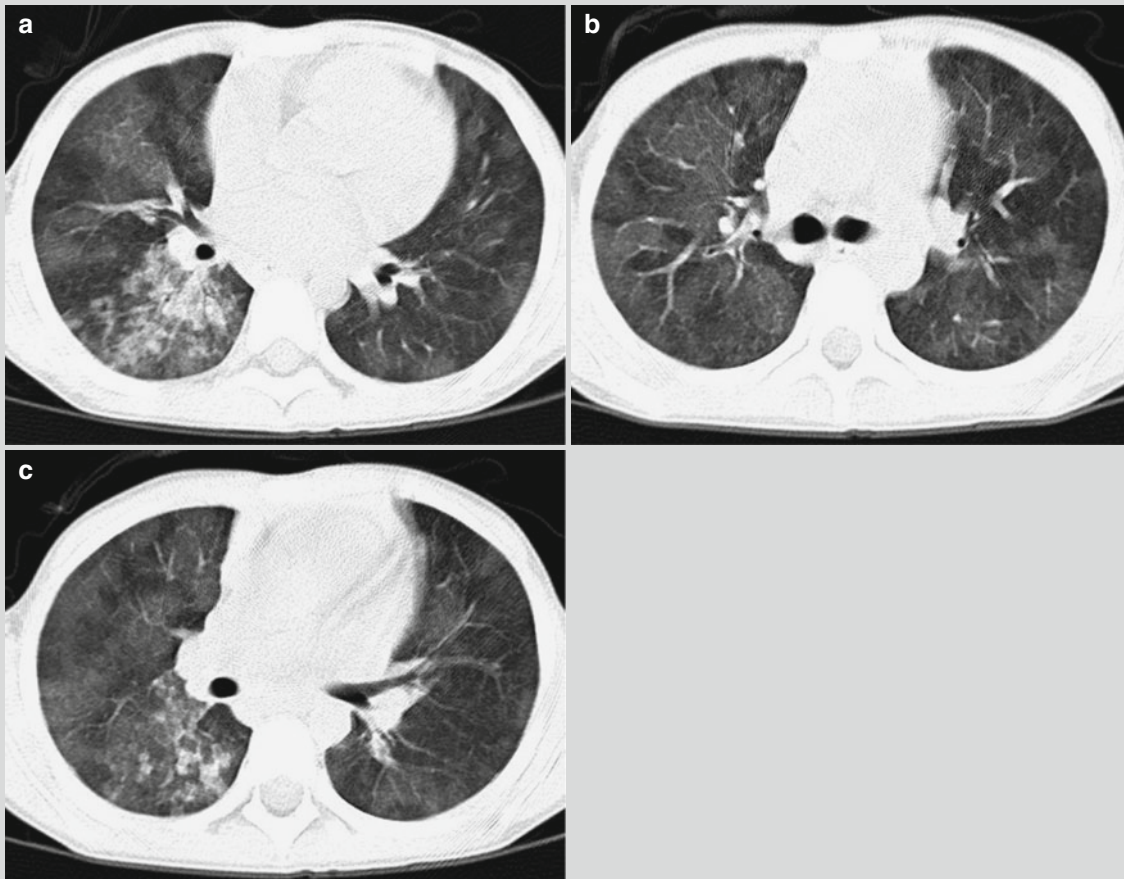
Pulmonary malaria with alveolar edema. (a–c) CT scanning demonstrates diffusive ground-glass opacities in both lungs
